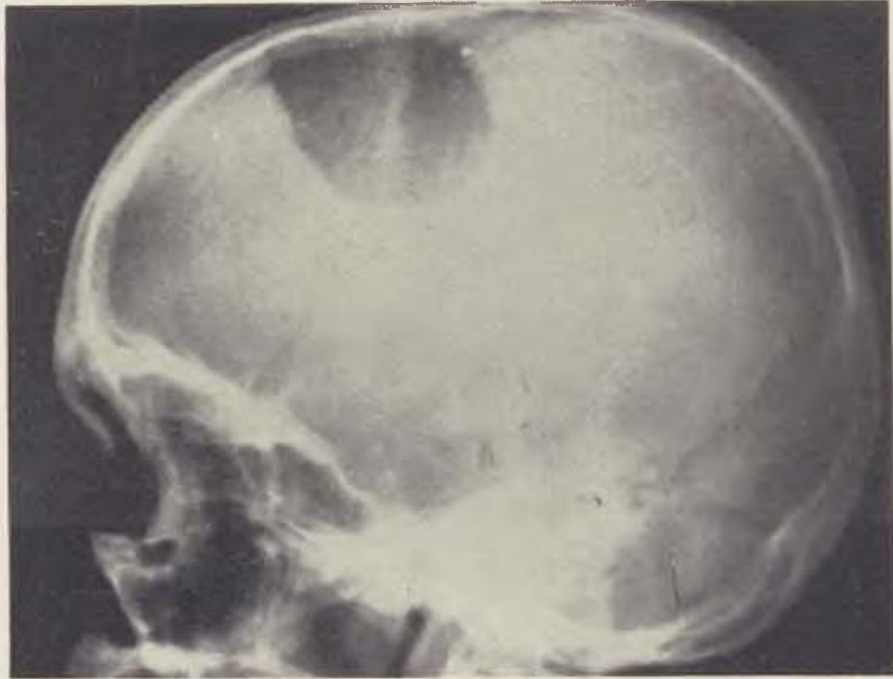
The same patient. X-ray after operation.
